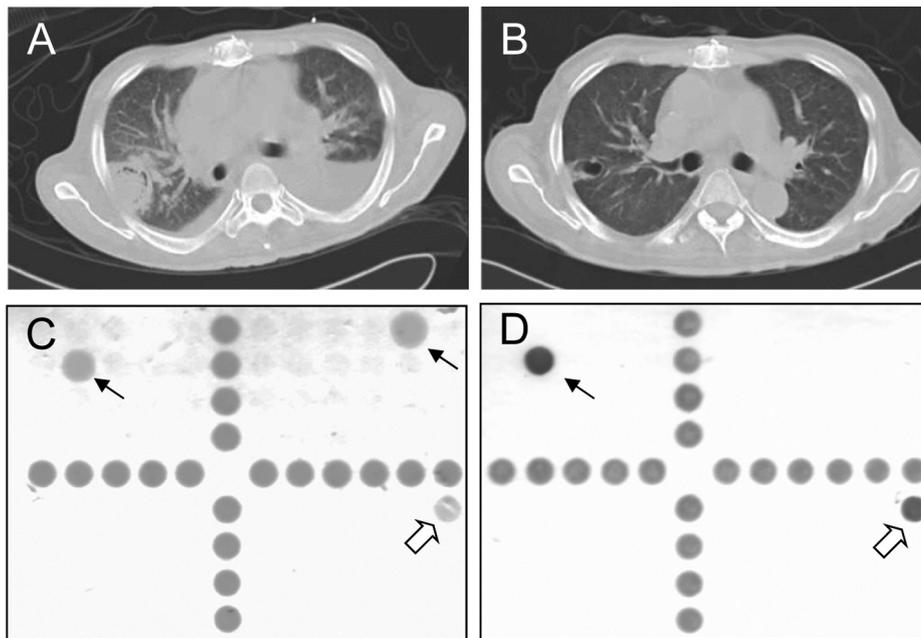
(A) Computed tomography shows a ball-in-hole lesion on the right lower lung. (B) After 3 months of voriconazole therapy, the lung lesion resolved. (C) Direct detection of fungi in sputum by the oligonucleotide array. The signals of *Aspergillus fumigatus* (right) and *Aspergillus terreus* (left) are indicated by the arrows, while the hollow arrow indicates the positive control. (D) Identification of the fungus isolated from sputum by the array. The signal of *A. terreus* is indicated by the arrow, while the hollow arrow indicates the positive control.
